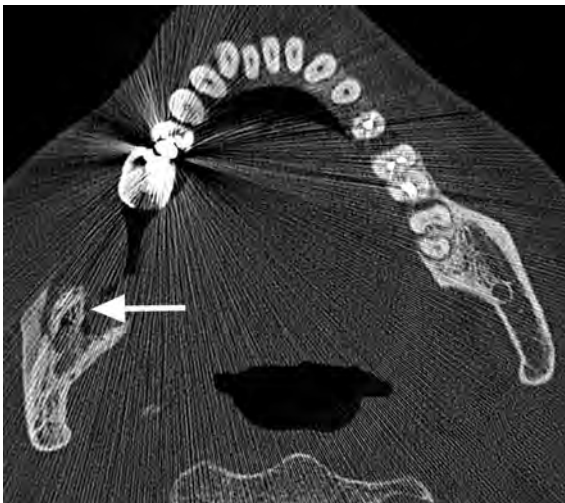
Intrinsic lesion of the right mandible in a 69-year-old female with dysaesthesia of the right V3 territory caused by bisphosphonates related osteonecrosis. Axial CT image in bone-window-level setting shows lamellating periosteal reaction and sclerosis and fragmentation of the right ascending ramus of the mandible (*arrow*)
